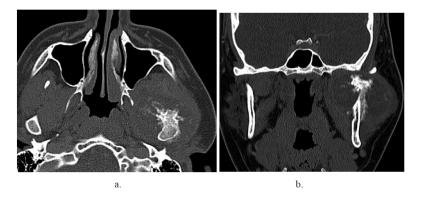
(case 14). Osteosarcoma in a 24-year-old male patient. (a) Axial and (b) coronal maxillofacial computed tomography examination demonstrating a heterogeneous mass lesion compatible with osteosarcoma in the left mandible condyle-ramus localization with osseous components that fill the left masticator distance and show radial extension from the mandible.
